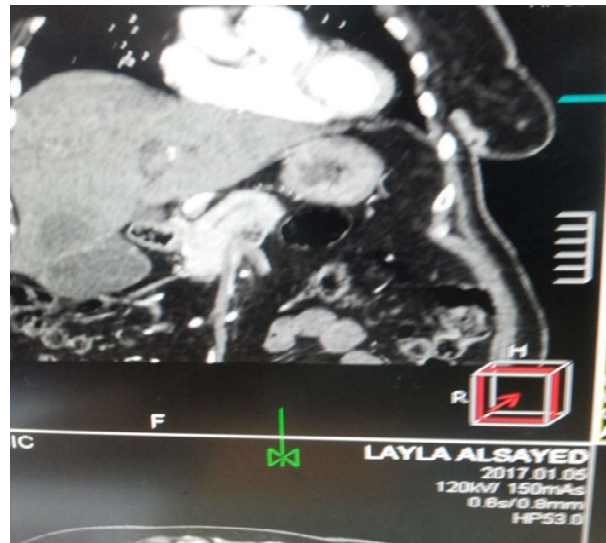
CT scan showing the origin of CA from the RHA.
